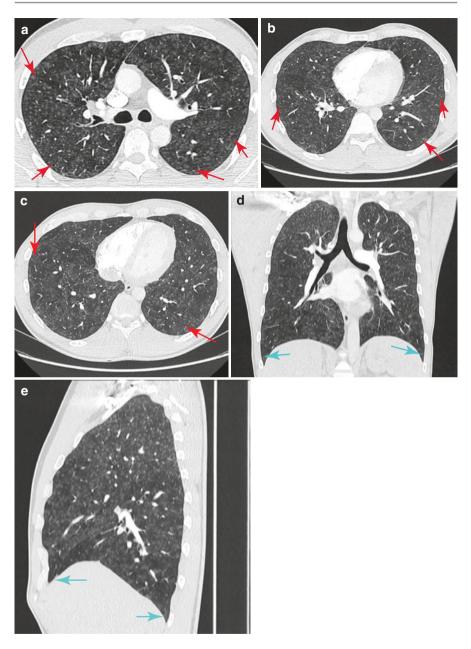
(a) HRCT of the lungs: bilateral multiple fine nodules in centrilobular. (b) HRCT of the lungs: bilateral multiple nodules in centrilobular distribution. (c) HRCT of the lungs: bilateral multiple fine nodulations in centrilobular distribution. (d) HRCT of the lungs (coronal reconstruction): centrilobular nodules conserving costophrenic angles. (e) HRCT of the lungs (sagittal reconstruction): nodules conserving costophrenic angles
